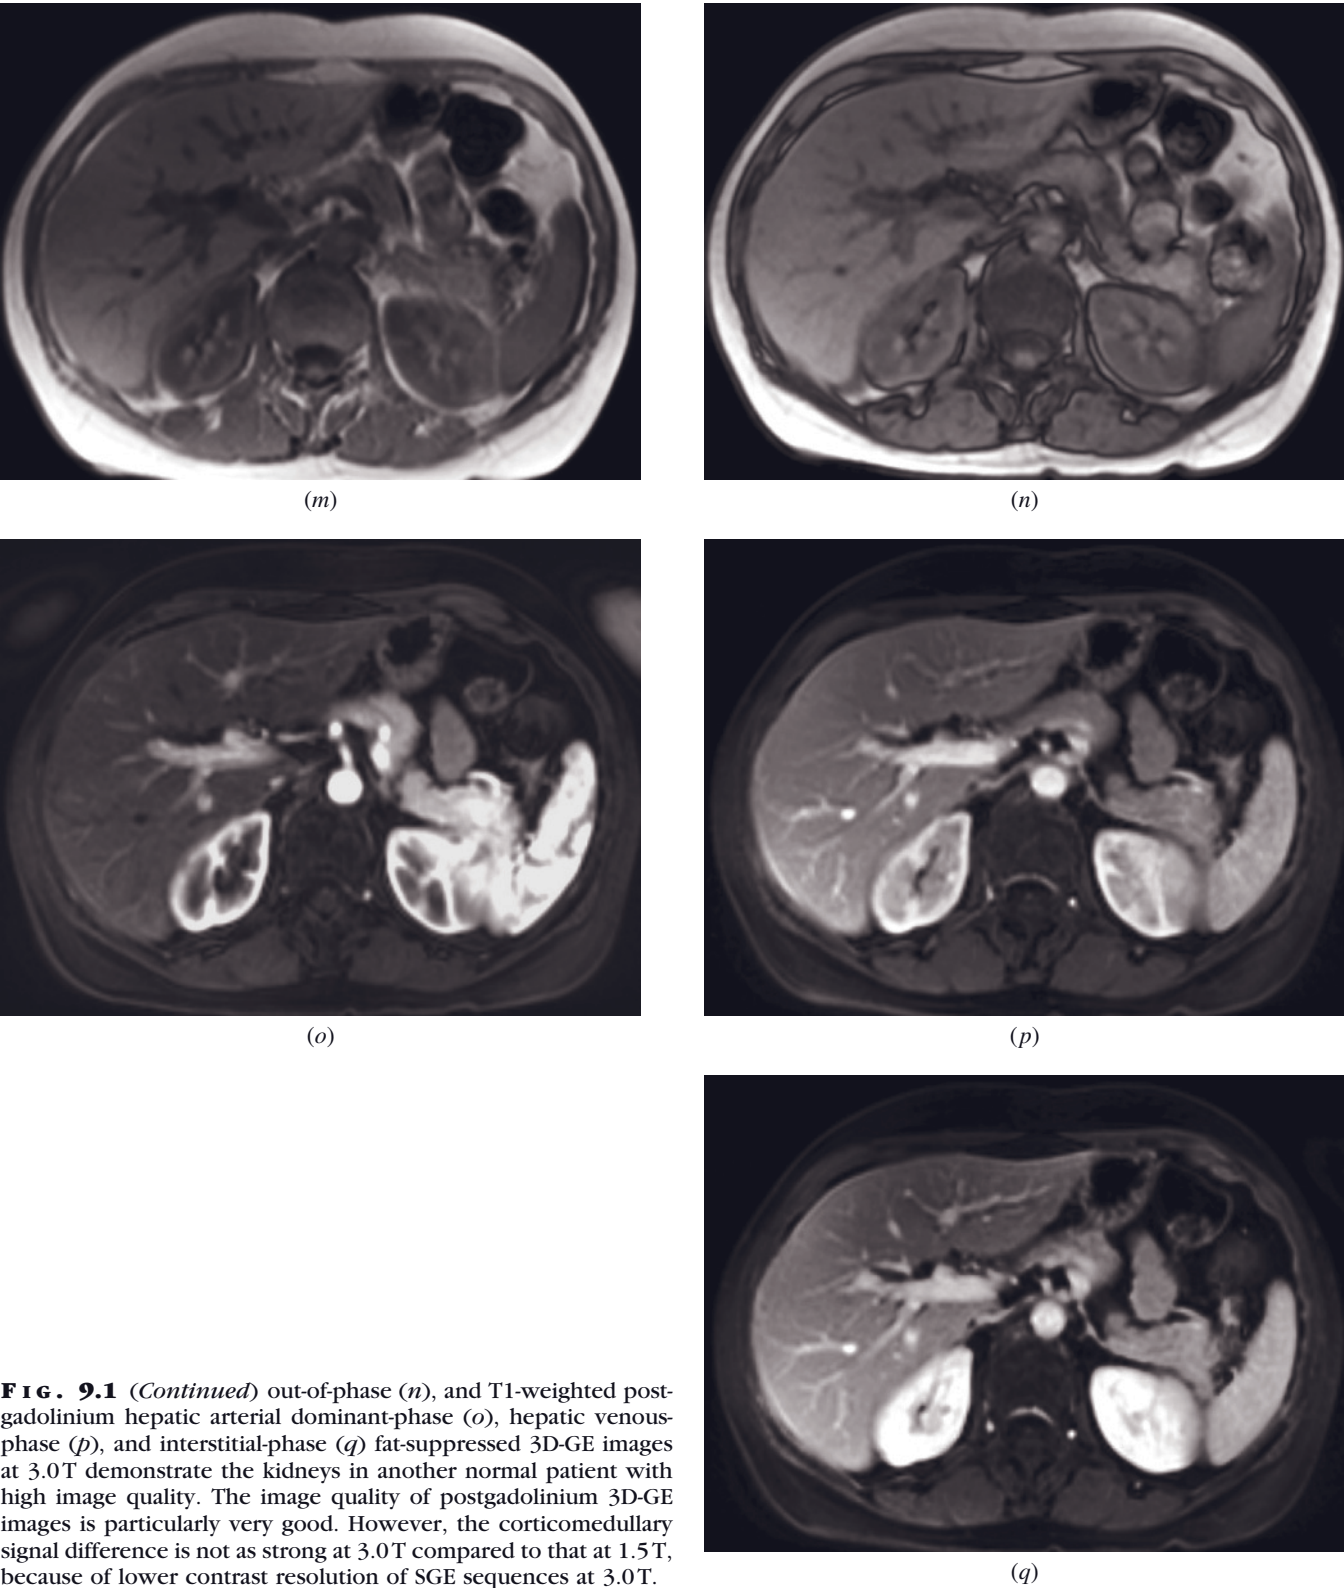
(*Continued*) out-of-phase (*n*), and T1-weighted post-gadolinium hepatic arterial dominant-phase (*o*), hepatic venous-phase (*p*), and interstitial-phase (*q*) fat-suppressed 3D-GE images at 3.0T demonstrate the kidneys in another normal patient with high image quality. The image quality of postgadolinium 3D-GE images is particularly very good. However, the corticomedullary signal difference is not as strong at 3.0T compared to that at 1.5T, because of lower contrast resolution of SGE sequences at 3.0T.
